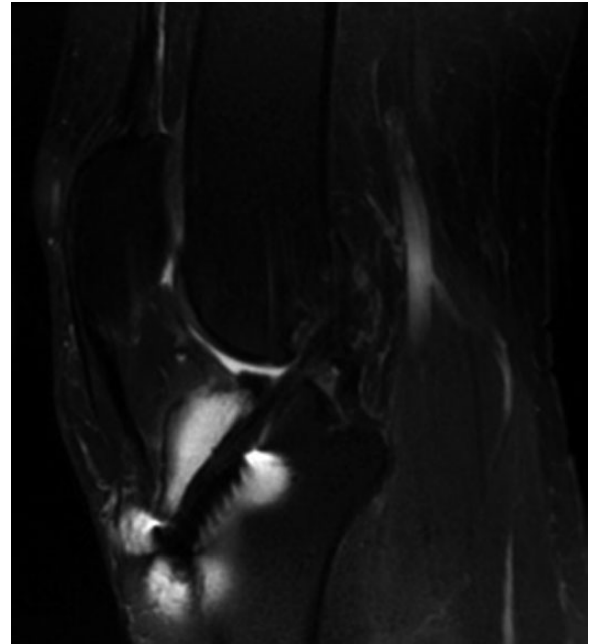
Sagittal magnetic resonance imaging knee view showing the graft (neoligament) after an anterior cruciate ligament reconstruction. Despite the presence of artifacts from previous fixation with metal interference screws, it is possible to visualize the anterior cruciate ligament graft.
